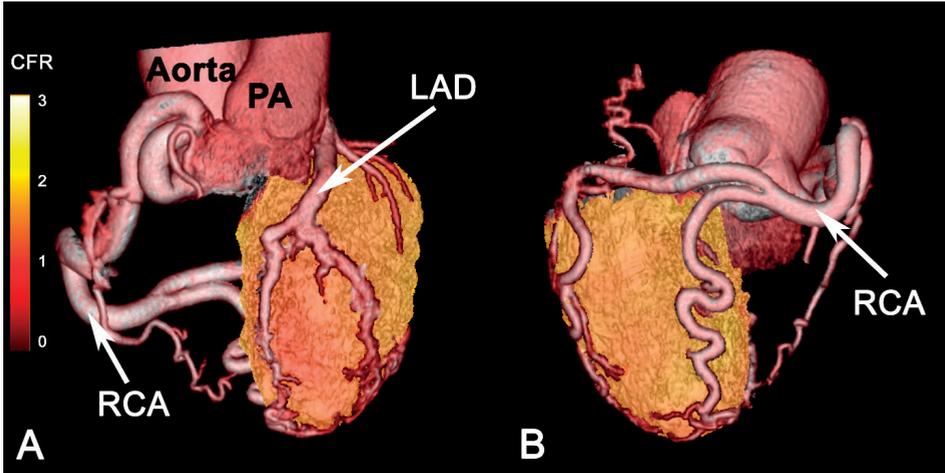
Fused CCTA/PET-MPI including coronary flow reserve of patient no. 1 with Bland-White-Garland syndrome (anomalous left anterior descending artery origin from the pulmonary artery). On panel A CFR in the territory of the anomalous vessel (i.e. LAD) perfusion is impaired to a greater extent compared to the non-anomalous vessel perfusion territory of the right coronary artery on panel B. CFR = Coronary flow reserve; MBF = Myocardial blood flow; PA = Pulmonary artery, LAD = Left anterior descending artery; RCA = Right coronary artery; CCTA = Coronary computed tomography angiography; PET-MPI = Positron emission tomography myocardial perfusion imaging
